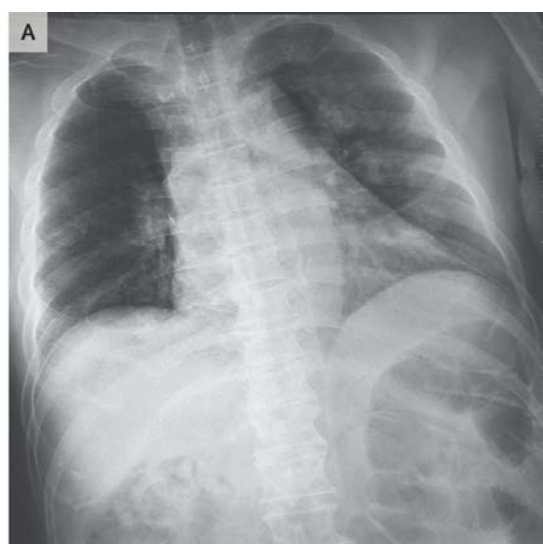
X-ray image of COVID-19 patient.
